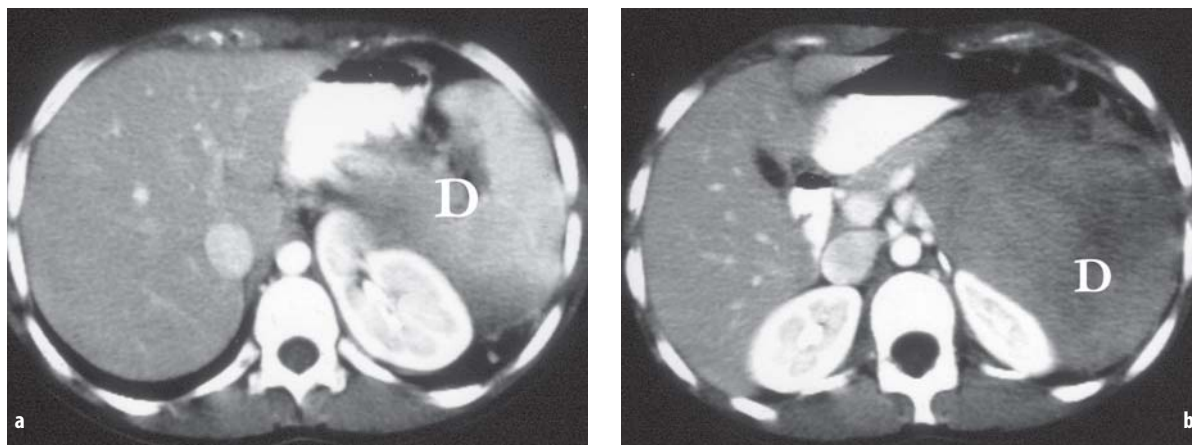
Preoperative computed tomography (CT) scan. D, desmoid tumour
